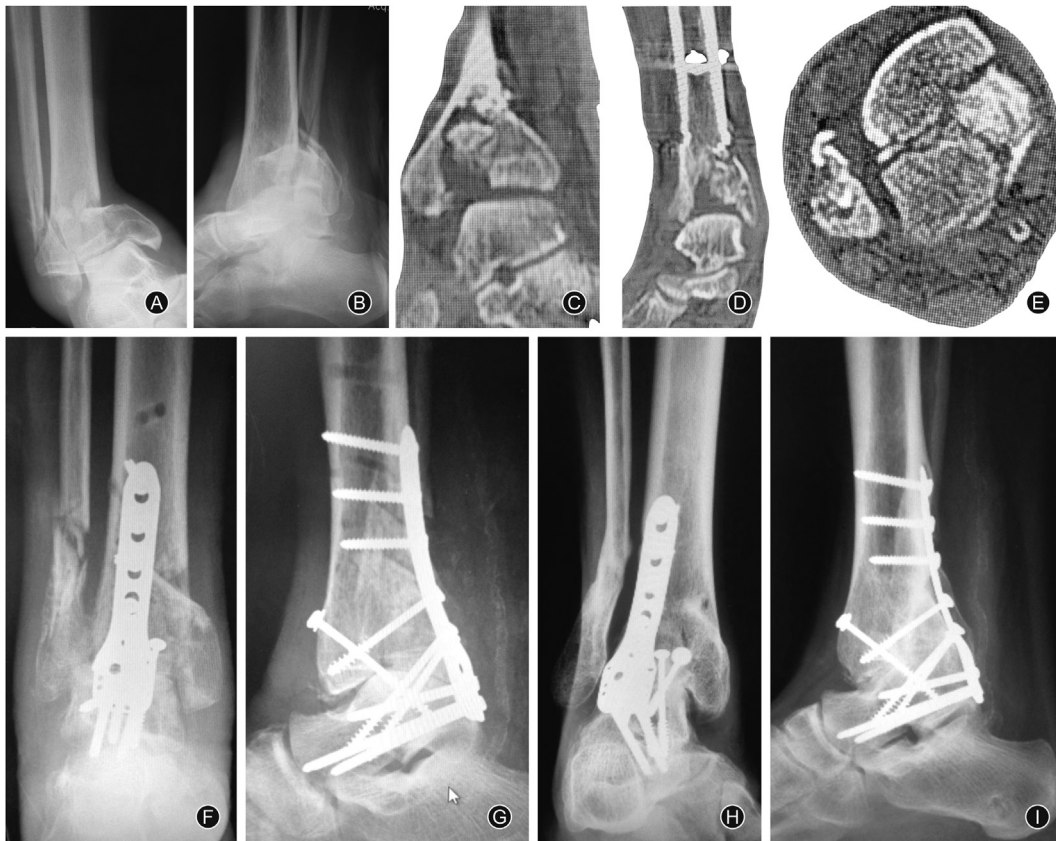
Case 4: a primary ankle arthrodesis with a proximal humeral locking plate resting on the posterior surface of the tibia. (A) and (B): Radiographs in anteroposterior and lateral views showing a complex tibial pilon fracture with varus deformity. (C-E): CT-scan on sagittal, coronal, and axial views showing fracture comminution. (F) and (G): Radiographs in anteroposterior and lateral views showing ankle fusion with a posteriorly placed, upside down proximal humeral locking plate (Philos plate, DePuy Synthes®). (H) and (I): Radiographs in anteroposterior and lateral views showing ankle fusion.
